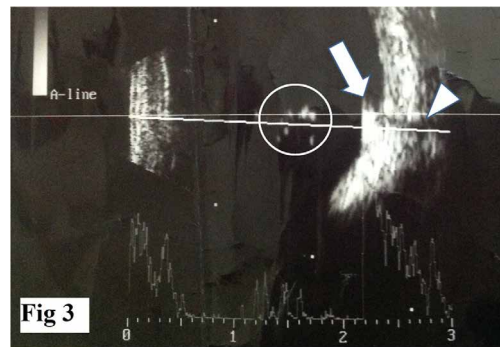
Sonography showing the intraocular foreign body (white arrow) with corresponding high spike on A Scan and acoustic shadow (white arrow head). Vitreous Debris are also seen in the centre (white circle).
